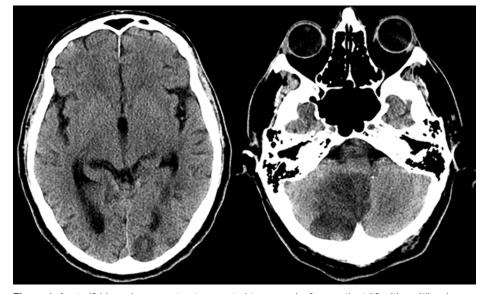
Acute (24 hours) non-contrast computed tomography from patient #3 with multilevel posterior circulation strokes.
